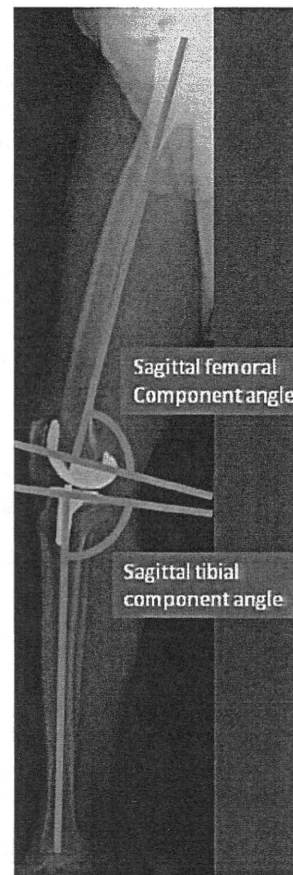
Full-length standing lateral radiograph. The parameters assessed in the sagittal plane are sagittal femoral component angle and sagittal tibial component angle
